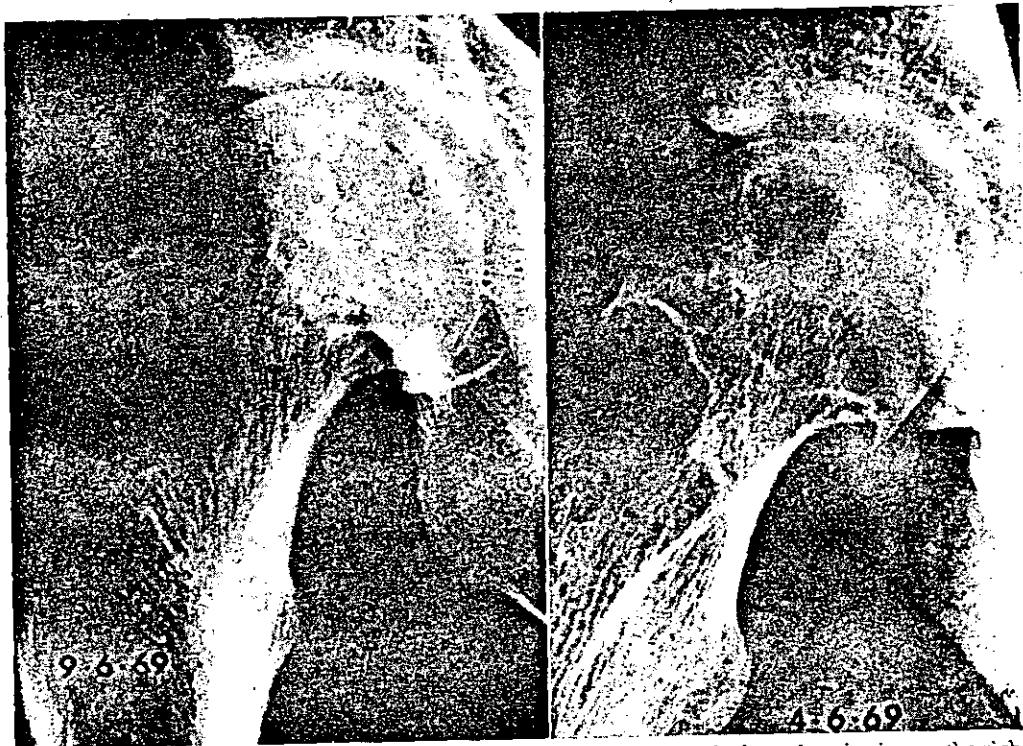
Same case 4 years later. On the left an A.P. radiograph and the lateral projection on the right shows sequestration of a large portion of the postero-superior aspect of the articular surface. This is bounded by a dense serpiginous layer inferiorly.
